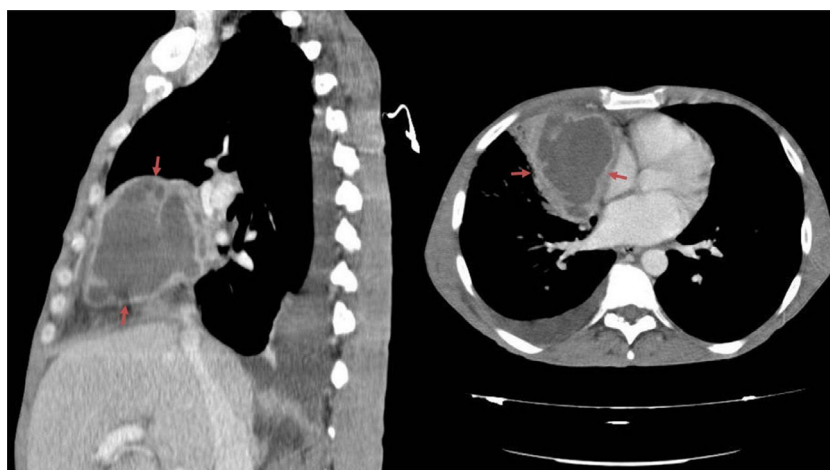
Chest CT. Anterior mediastinal mass with necrotized areas of infected embryonic remnants.
